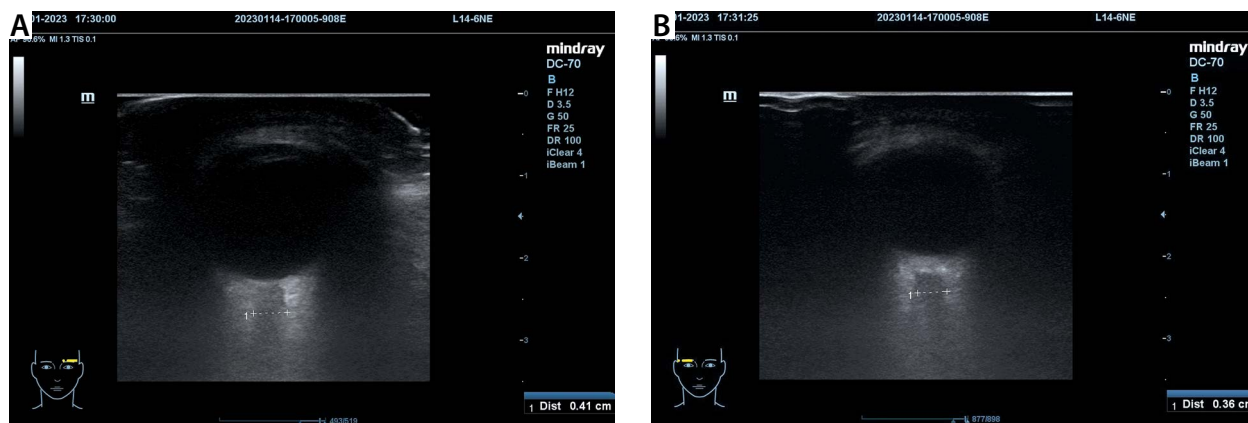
A – Ultrasound image of the left ocular and optic nerve sheath on the left side, Mindray ultrasound machine, L14-6NE transducer. Examination performed by MWM. B – Ultrasound image of the right ocular and optic nerve sheath on the right side. Mindray ultrasound machine, L14-6NE transducer. Examination performed by MWM
